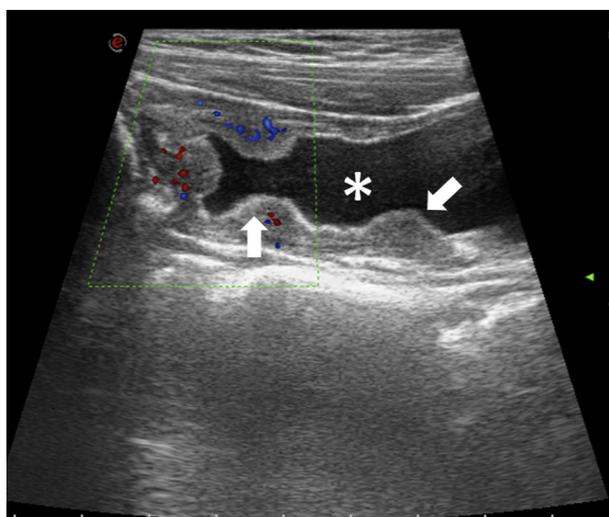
Bladder granulomas on ultrasonography. The asterisk shows the bladder lumen and the arrows show foci of nodular hyperplasia of the bladder walls, with enhanced Doppler signal.
